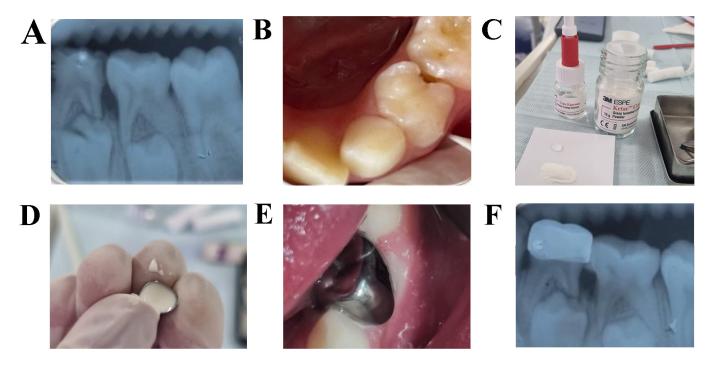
Clinical sequence of the hall technique placement. (A) Radiograph of the carious lesion on tooth 74. (B) Prophylaxis on tooth 74. (C) Manipulation of the Ionomer. (D) Placement of the Ionomer in the Hall crown. (E) Installation of the crown. (F) Radiograph after installation.
